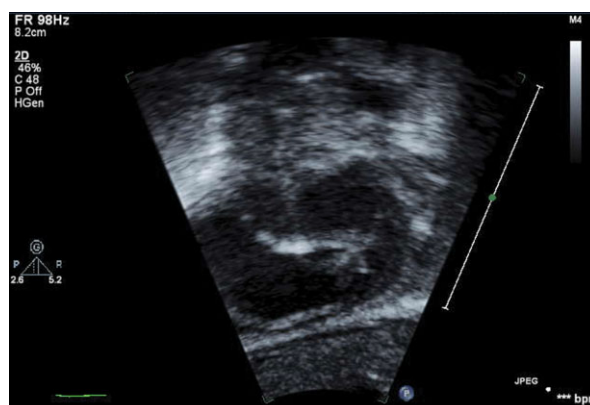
Transthoracic 2D echo with inflated septostomy balloon in the left atrium shows the catheter course from the superior vena cava across the superiorly oriented atrial septal defect into the left atrium.
